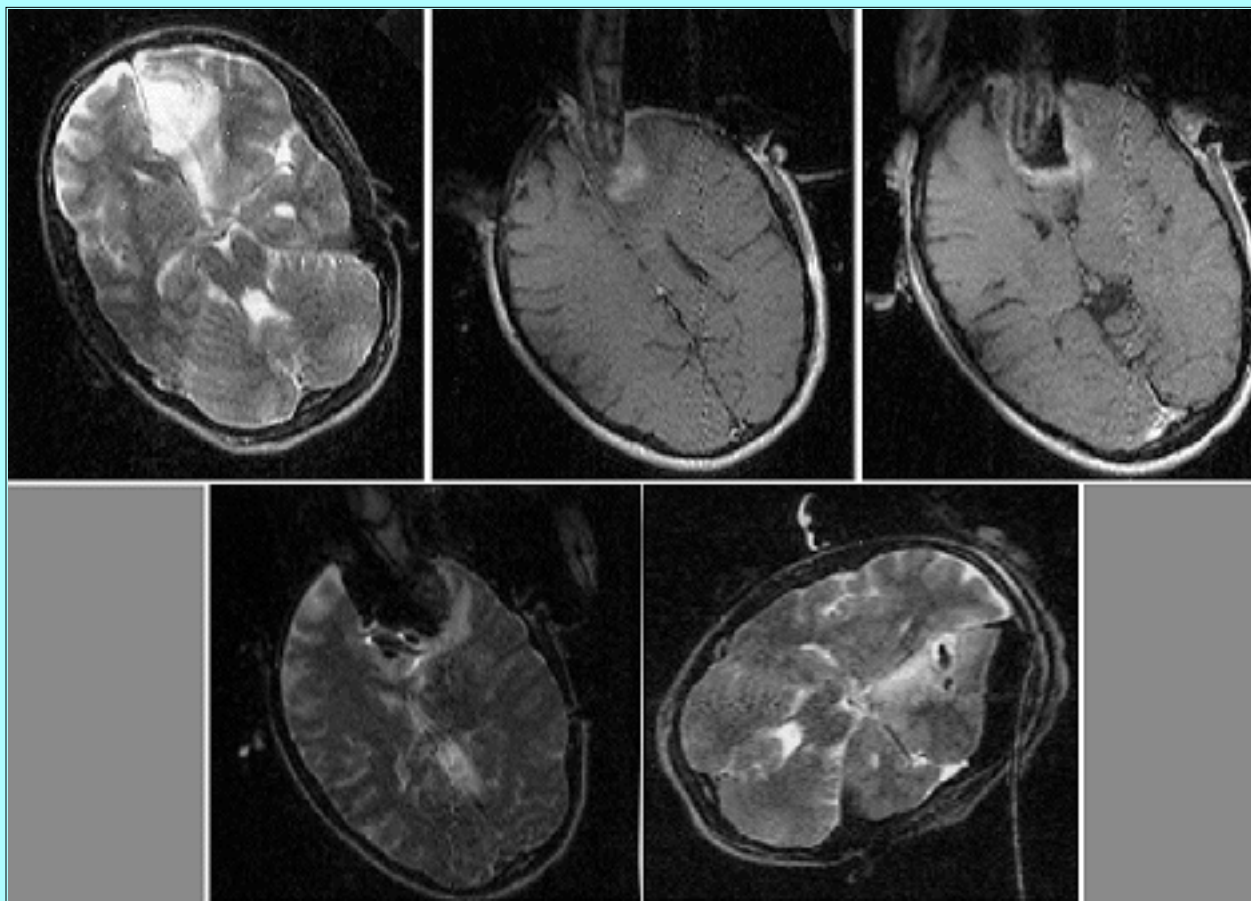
Magnetic resonance images showing resection of a left frontal oligoastrocytoma. A: Initial axial T₂-weighted intraoperative image showing the lesion. B and C: Axial T₁-weighted images showing finger localization to guide resection of abnormal tissue. D: A T₂-weighted image obtained to localize the lateral abnormal tissue. E: A T₁-weighted image obtained after closure. Note the shift in the brain tissue.
